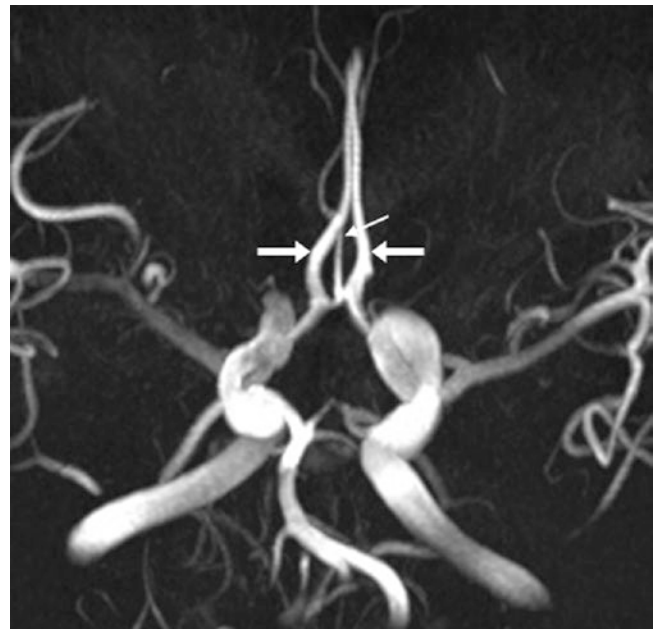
In this 73-year-old, a source 3DTOF MRA image (*left*) demonstrates three vessels (*arrows*) just above the AcoA, also shown on an axial T2WI (*left middle*). Source axial CTA images (*right middle*)
